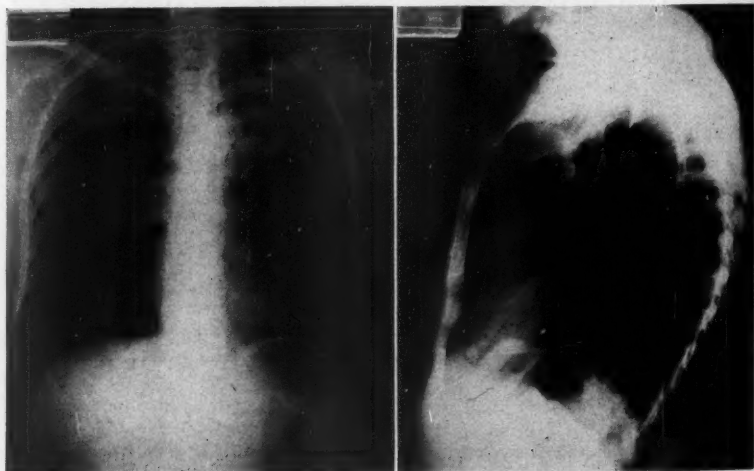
Case 5. Roentgenograms of the chest. Extensive disease of the left upper lobe.
